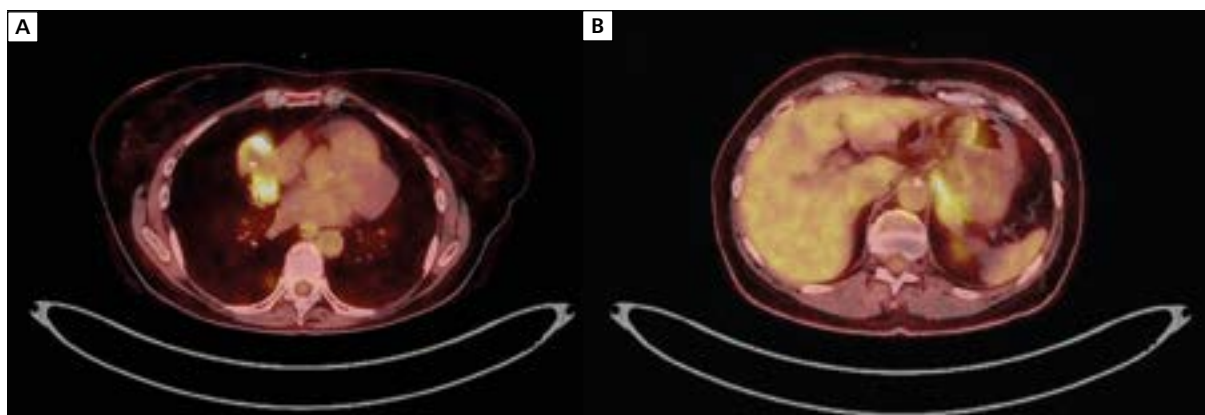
Positron emission tomography–computed tomography (PET-CT) scan images; A. An irregular nodal-infiltrative conglomerate in the right pulmonary hilum; B. Infiltration between the left adrenal gland and the stomach
